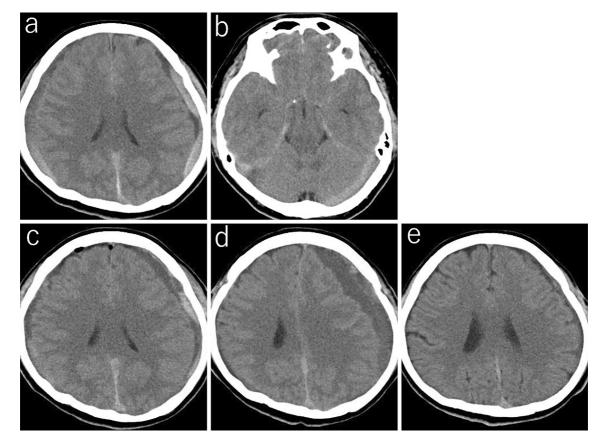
Brain CT images on admission revealed bilateral subdural hematoma (SDH) (a) and hyperdense lesions in the basal cistern and along the tentorium cerebelli (b). On day 11, SDH recurred after burr-hole evacuation was performed (c). On day 34, SDH enlarged (d). Following a lumbar epidural blood patch, SDH improved on day 100 (e).
